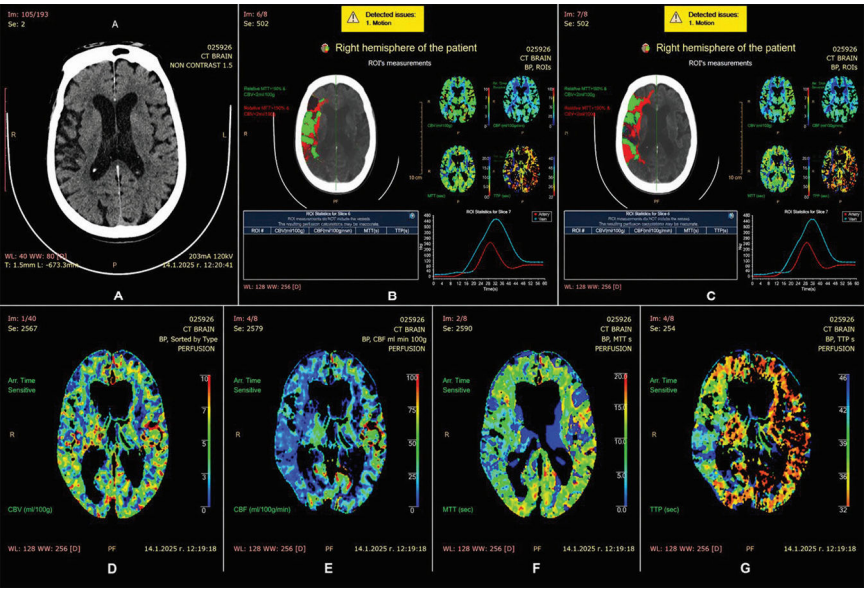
Non-contrast CT (A) and perfusion maps (B-G) demonstrating ischemic changes in the right MCA territory. Perfusion maps show prolonged MTT and reduced CBV, with decreased cerebral blood flow. Findings are consistent with ischemic penumbra and infarct core
